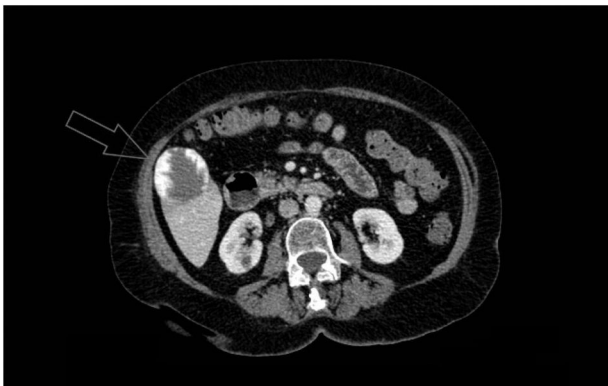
Axial view of the abdominal CT scan with iv contrast medium: focal lesion with peripheral nodular enhancement (approximately 5.1×4.6 cm) located in liver segment V, consistent with an exophytic hemangioma.
